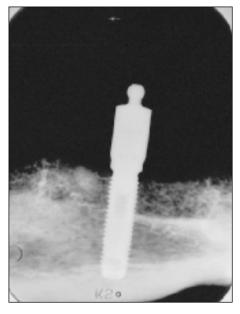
Radiograph of left mandibular molar region site of mandible reconstructed with full-thickness calvarial bone.
